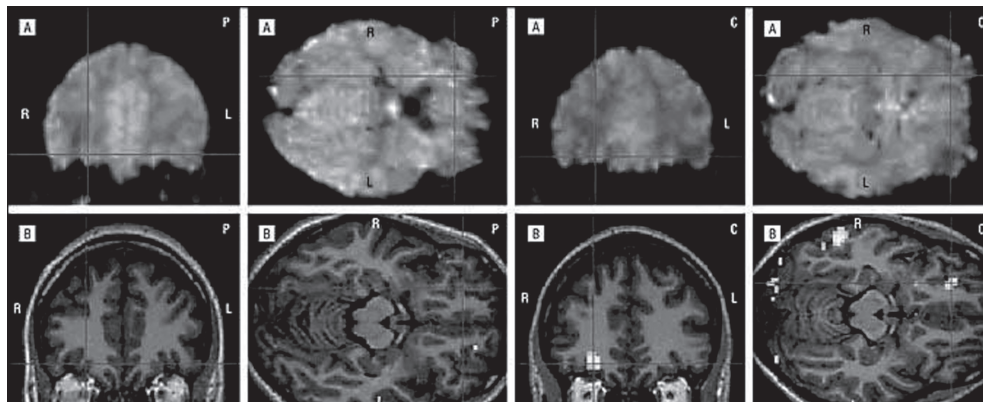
Examples of mean echo-planar images (coronal and axial slices) acquired with the orbitofrontal cortex (OFC)-sensitive sequence (A) in a 27-year-old female patient (P) and a 28-year-old female control subject (C) and of their main effects for reward (correct responses – baseline trials) superimposed on each subject's individual normalized structural magnetic resonance imaging scan (B). All slices were at the same level of the OFC; crosshairs were at $x = 24$, $y = 42$, $z = -15$. L indicates left; R, right.
